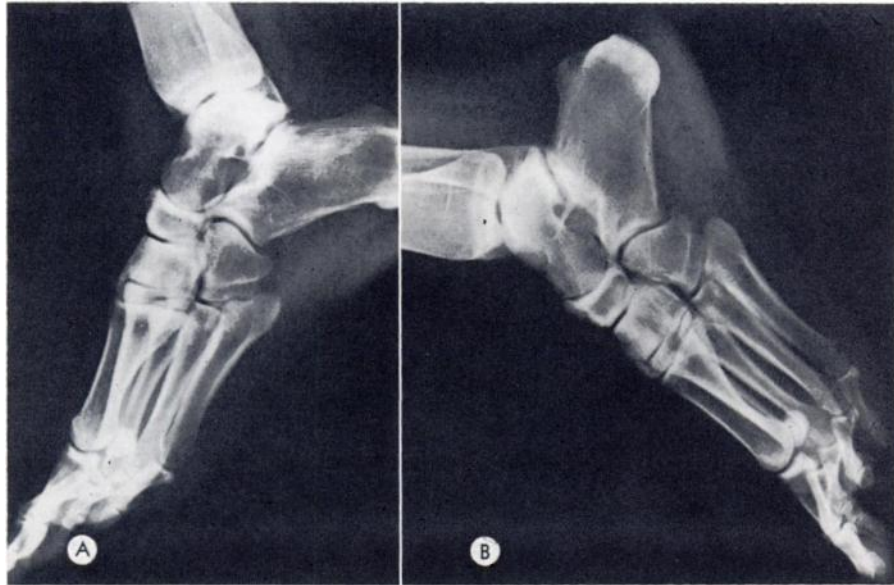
Case II. (*A* and *B*) Lateral roentgenograms of the feet. Faint linear striations are present in the calcaneus on the right as well as in the distal right tibia (*A*).
